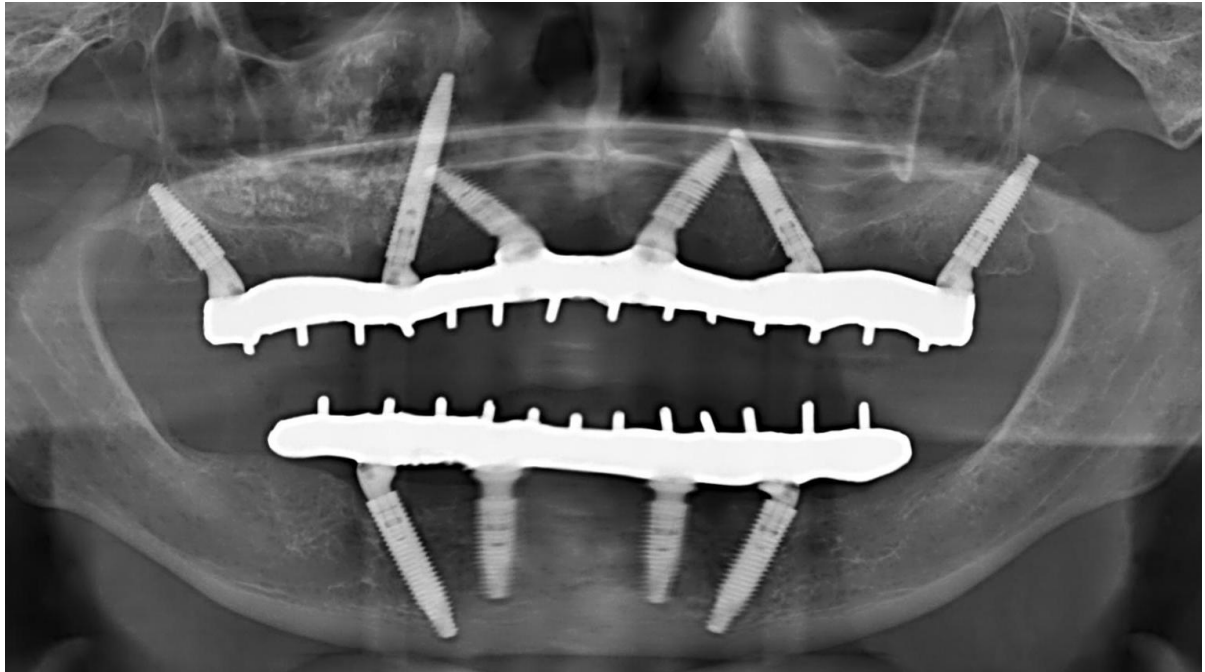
Postoperative panoramic radiograph obtained at prosthesis delivery.
